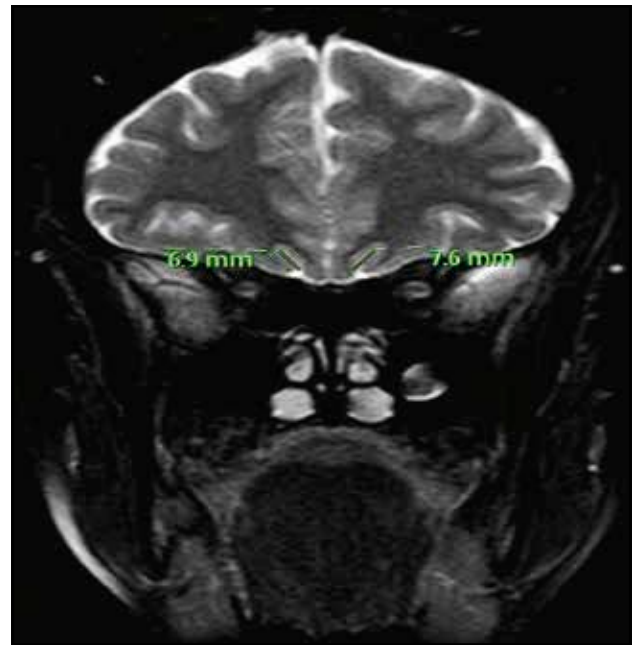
On coronal T2W FSE MRI scan, OS depth measurements are shown.
